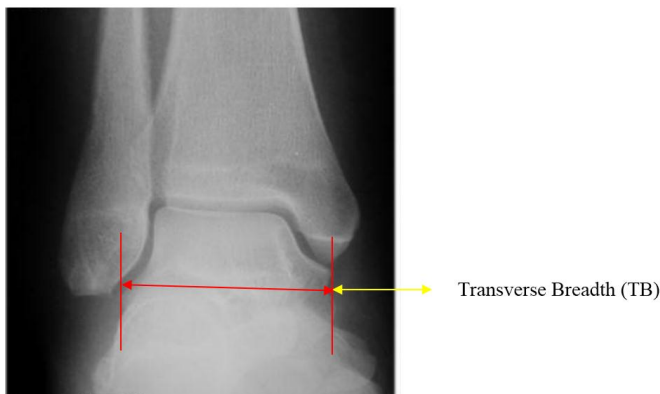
Antero-posterior Radiograph of the Ankle showing Transverse Breadth (red line): [10].
